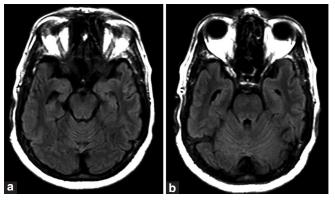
(a,b): Follow-up magnetic resonance imaging after six chemotherapy cycles showing significant resolution of cerebellar and vermian hyperintensities
